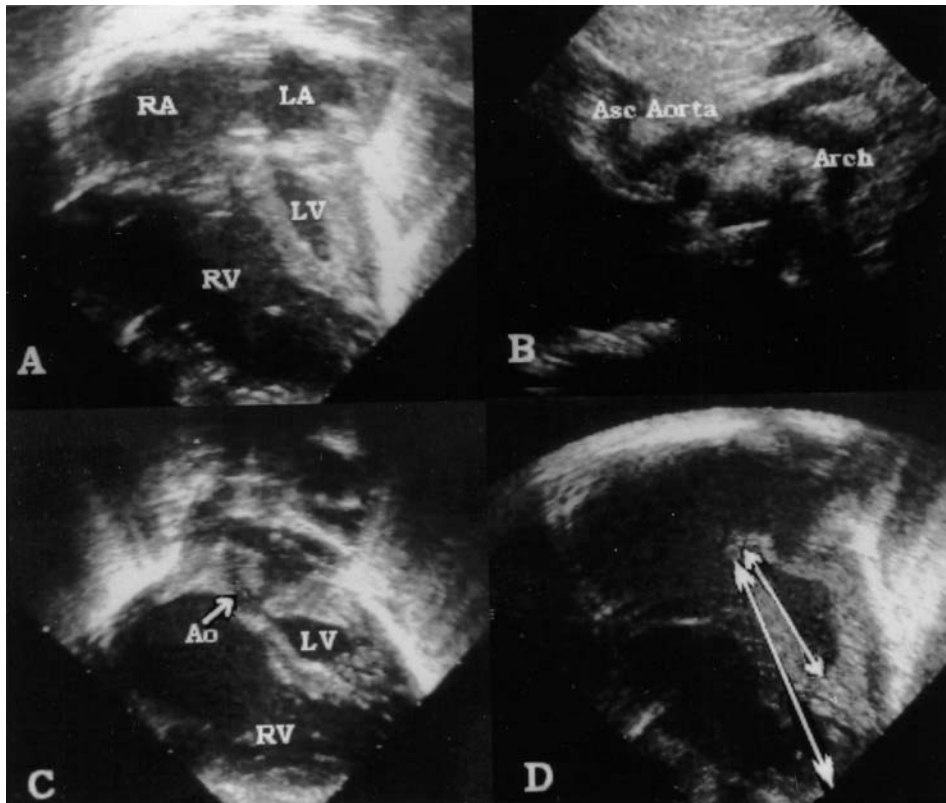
Echocardiographic frames from infants with hypoplasia of the left heart. A: Four-chamber view showing severe hypoplasia of the left ventricle. B: View of the aortic arch demonstrating the ascending aorta, which measures approximately 3 mm in diameter, and which is smaller than the arch. C: Four-chamber and aortic root view showing gross hypoplasia of the left ventricle and aortic root. D: Arrows demonstrate the measurements taken to calculate the ratio of the left-to-right ventricular long axis. Measurements are made from the endocardial surface of the apex of each ventricle to the hinge points of the mitral or tricuspid valve at the crux.
